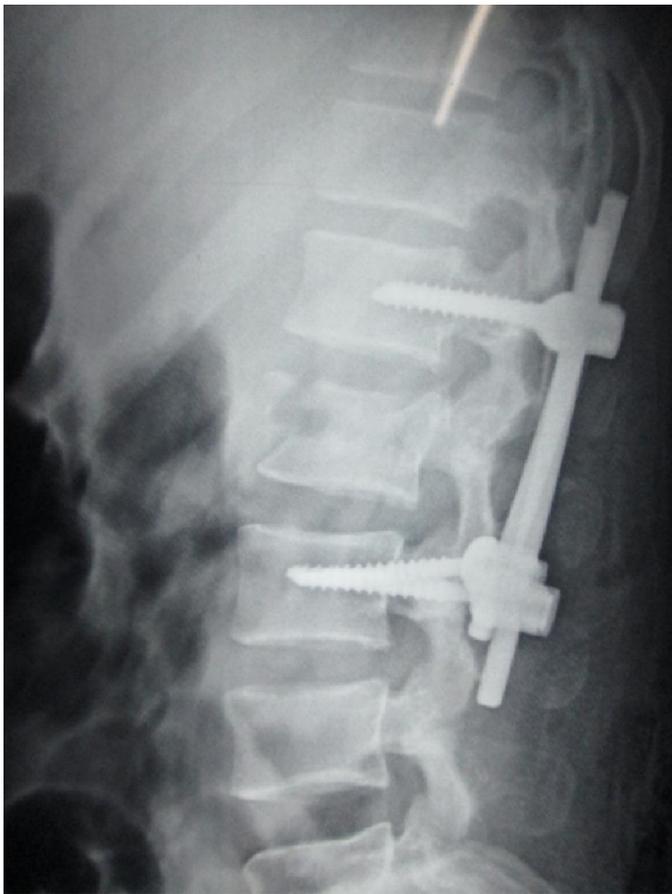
Post-operative X-ray of same patient showing restoration of kyphotic angle
